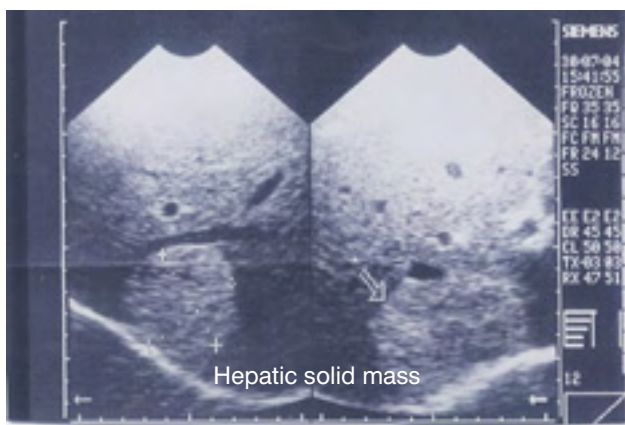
Ultrasonography: A solid hepatic mass was observed (arrow)
